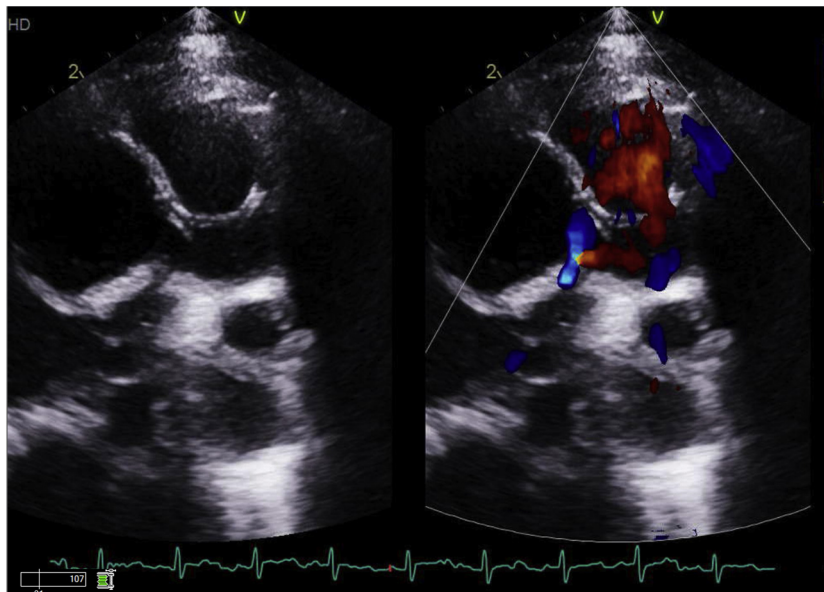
Transthoracic echocardiograms of a St Jude mechanical valve in the aortic position with washing jets.
